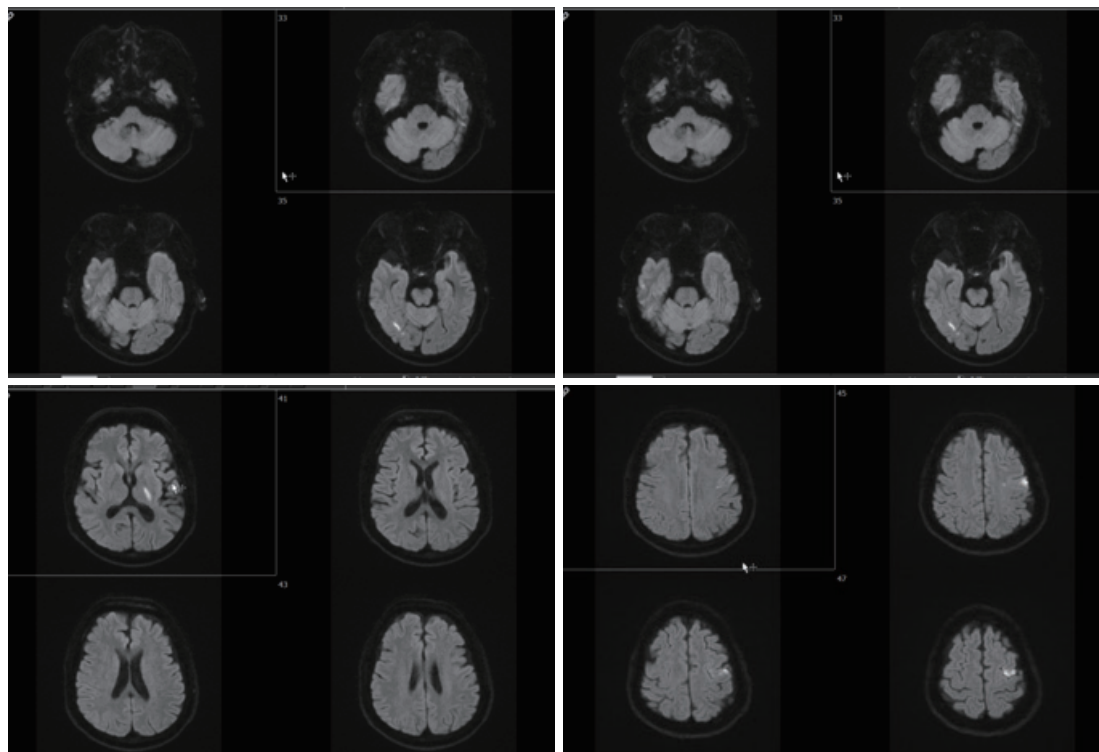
DWI of brain revealed multiple acute infarctions in bilateral hemispheres in both anterior and posterior circulation.
